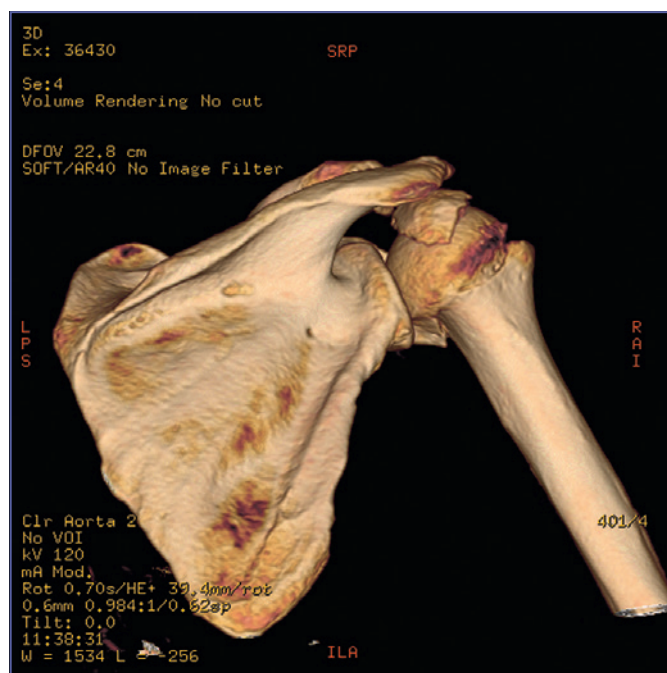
Same patient as Figure 1, preoperative CT study, posterior 3D reconstruction: 4 part humerus fracture.
